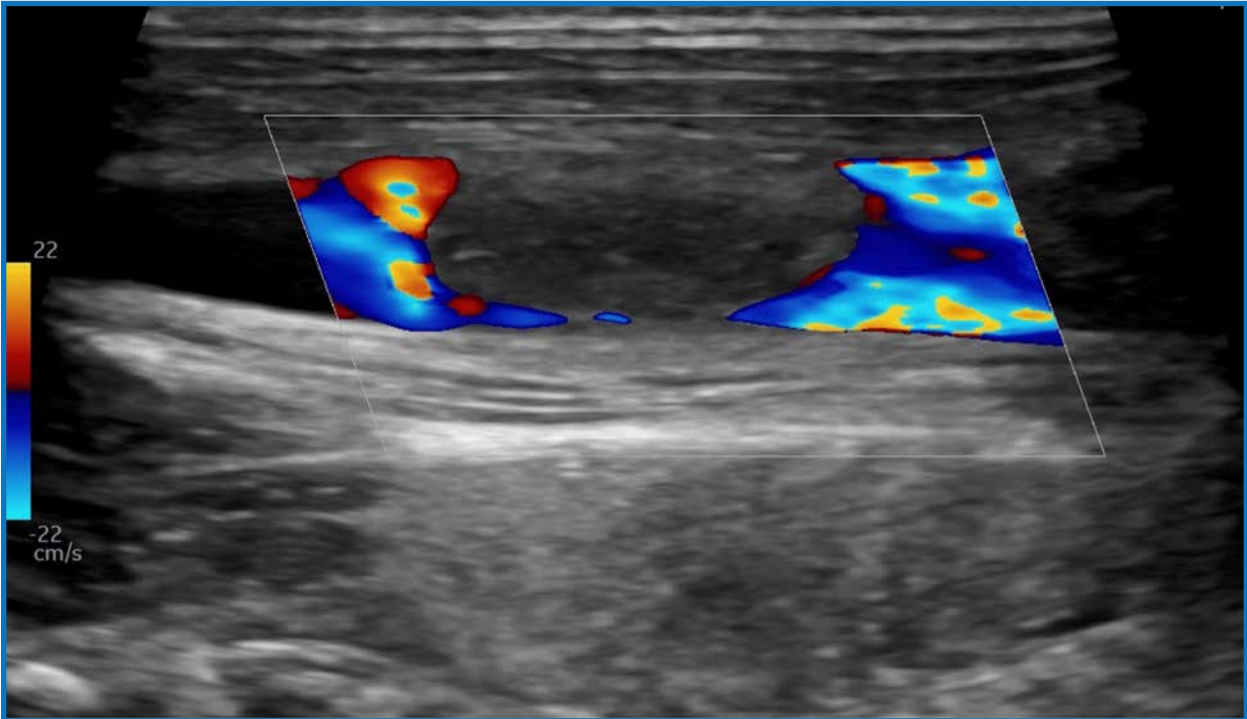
Neck ultrasound with Doppler in long axis view showing nonocclusive right internal jugular vein thrombus.
